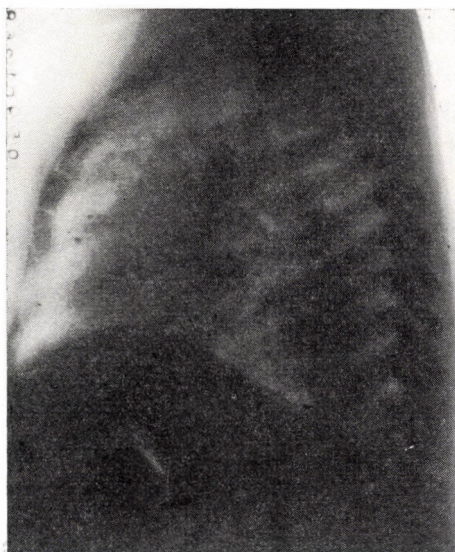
/b. The appearance of the former opacity in the frontal X-ray
